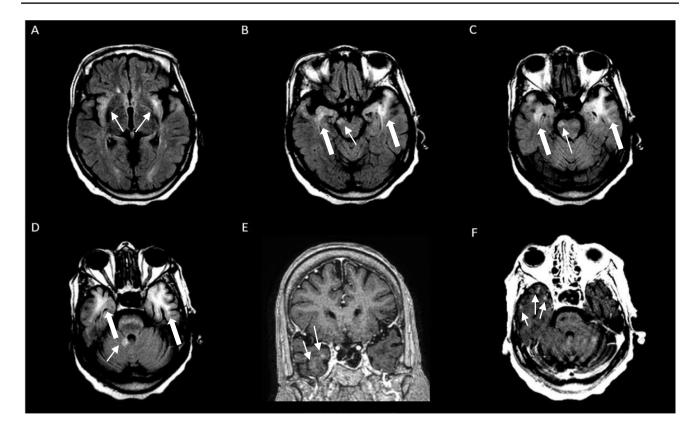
Axial T2-FLAIR-weighted sequence without contrast showing bilateral insular (A), bilateral anterior temporal lobes (B, C, D—thick white arrows), right cerebral peduncle of the midbrain (B), anterior pons (C), and right superior cerebellar peduncle hyperintensities
